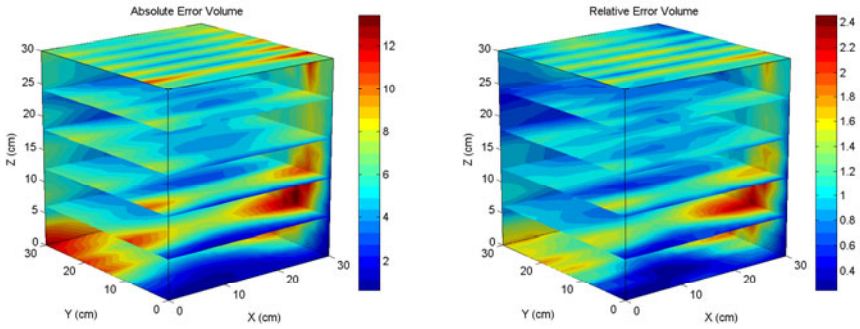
Absolute (left) and relative (right) error maps in a $30 \times 30 \times 30$ cm workspace of EM tracker in an interventional X-ray environment - colorbars are shown in mm
